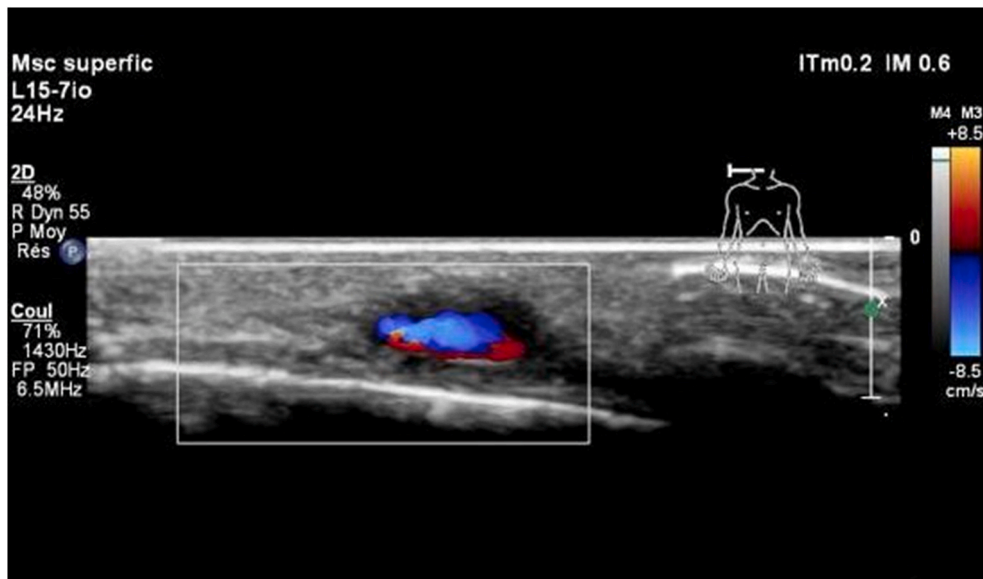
Ultrasound demonstrating blood flow in the lesion.
